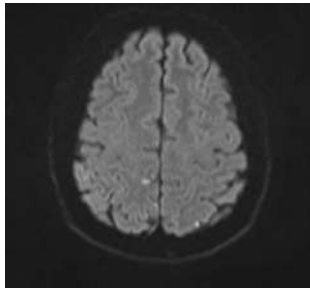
MRI scan Oct 2017 showing tiny multiple focal infarcts in the right medial parietal and left parieto-occipital lobes.
